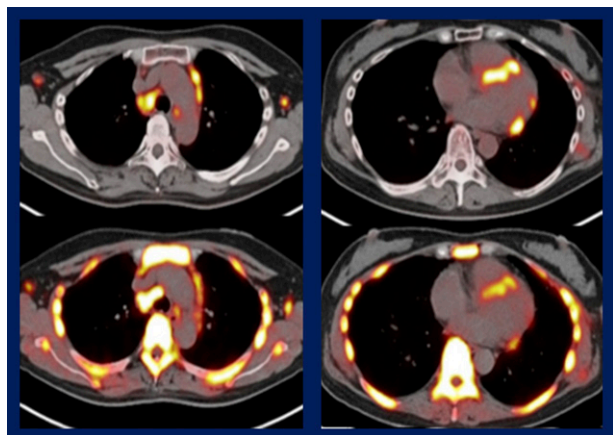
A representative case of ^{18}F -FDG PET/CT (top) and ^{18}F -fluorothymidine (^{18}F -FLT) PET/CT (bottom) in a patient with cardiopulmonary sarcoidosis. Both tracers accumulated nicely in pulmonary lymph nodes and cardiac lesions, although ^{18}F -FLT uptake was lower than that of ^{18}F -FDG in cardiac lesions.
